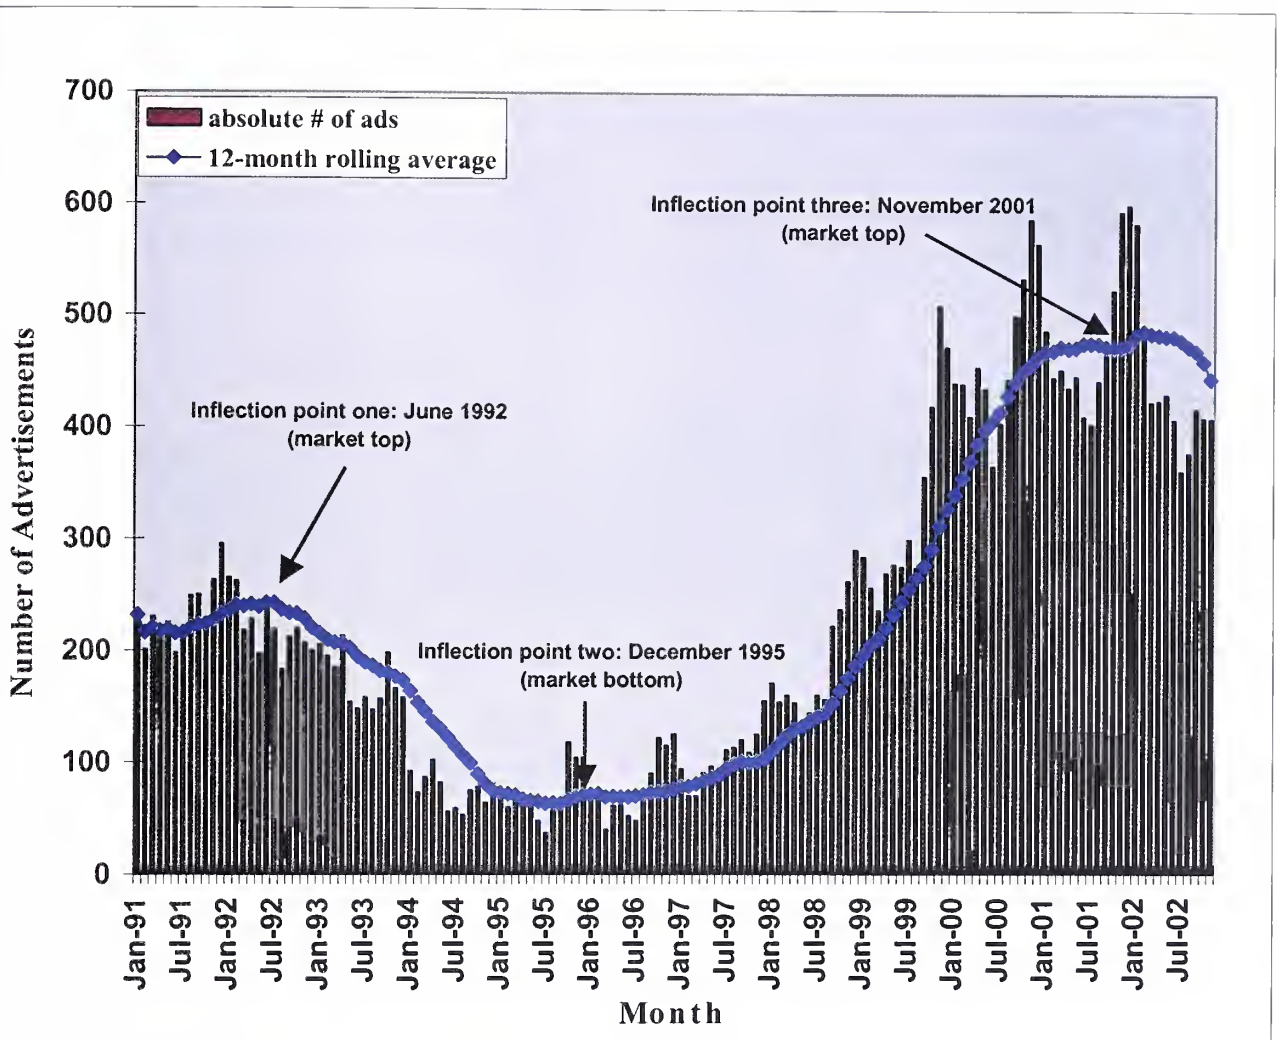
Graph shows actual number of advertisements (*bars*) per month in *American Journal of Roentgenology and Radiology* from January 1991 through December 2002, with 12-month rolling average (*thick line*) calculated to reduce seasonal variation. Note that the rolling average peaked in the summer of 1992, bottomed out at the end of 1995, and peaked again during the fall of 2001. There is a clear downtrend in the rolling average from February to December 2002. Jan = January, Jul = July.
